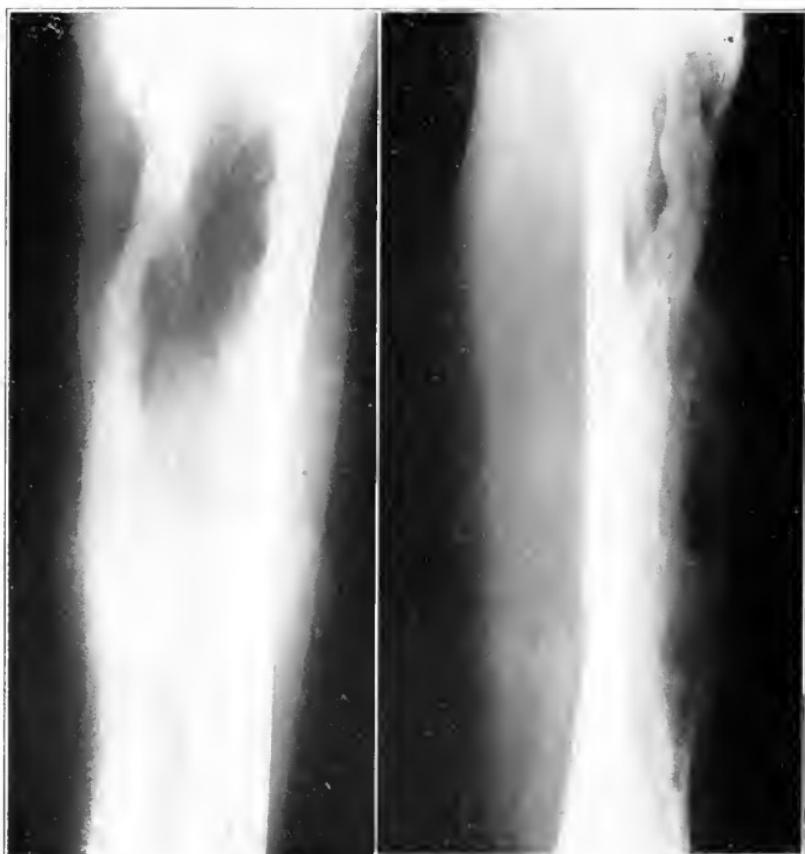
(Case 2).—Roentgenogram taken, April 10, 1920; new bone proliferation about and incorporating former dead shaft.
